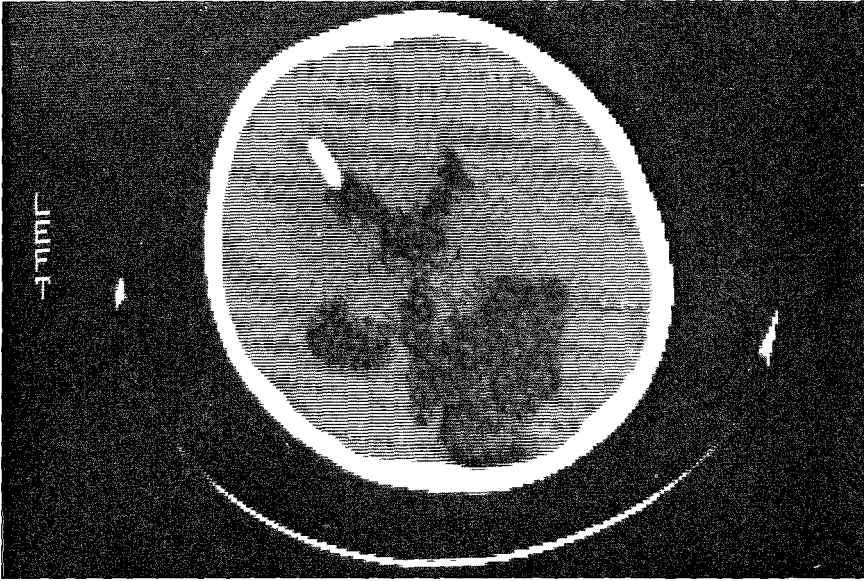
CT scan showing a large right parieto-occipital porencephalic cyst with hydrocephalus. The tip of the ventricular catheter was in the brain parenchyma of the frontal lobe.
